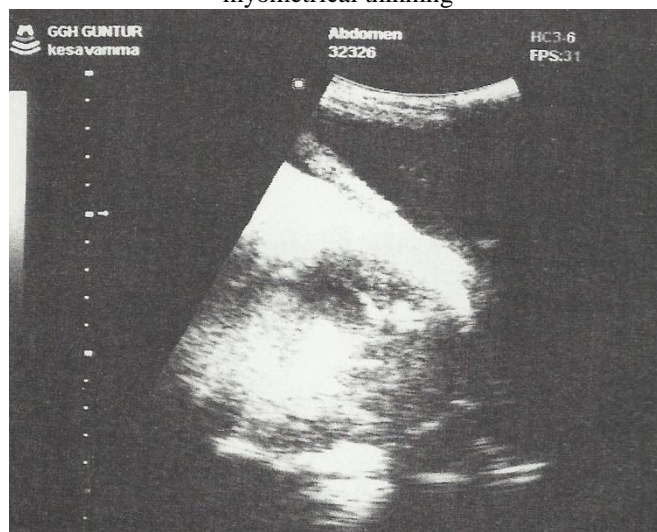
Longitudinal sonogram showing adhesions to the scar
